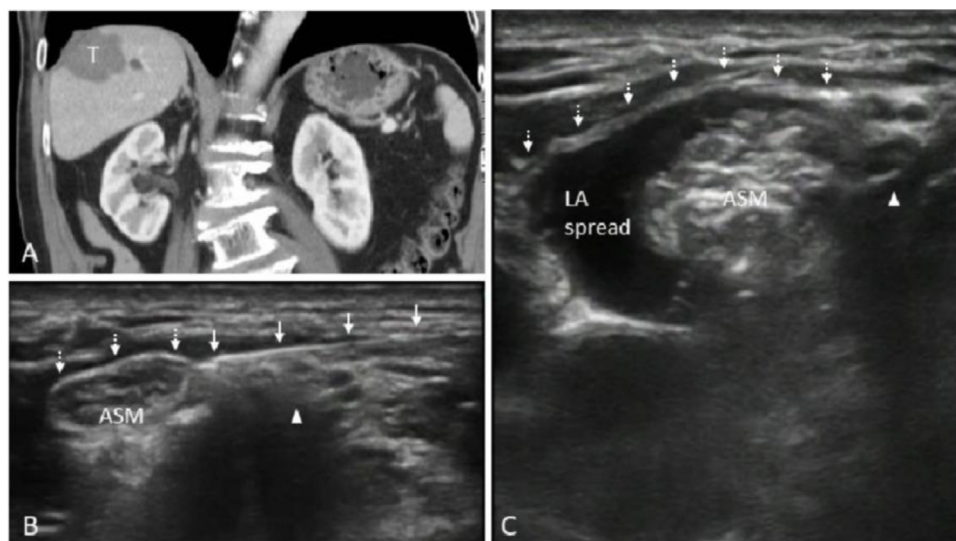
(A) Coronal plane of computed tomography of the diaphragm-abutting tumor. (B) Pre-injection ultrasound image before puncturing the prevertebral fascia. (C) Post-injection ultrasound image with a perimuscular spread beneath the prevertebral fascia. Arrowhead indicates the superior trunk, solid arrow indicates the needle shaft, and broken arrow indicates prevertebral fascia. T, Tumor; ASM, Anterior Scalene Muscle; LA, Local Anesthetic.
